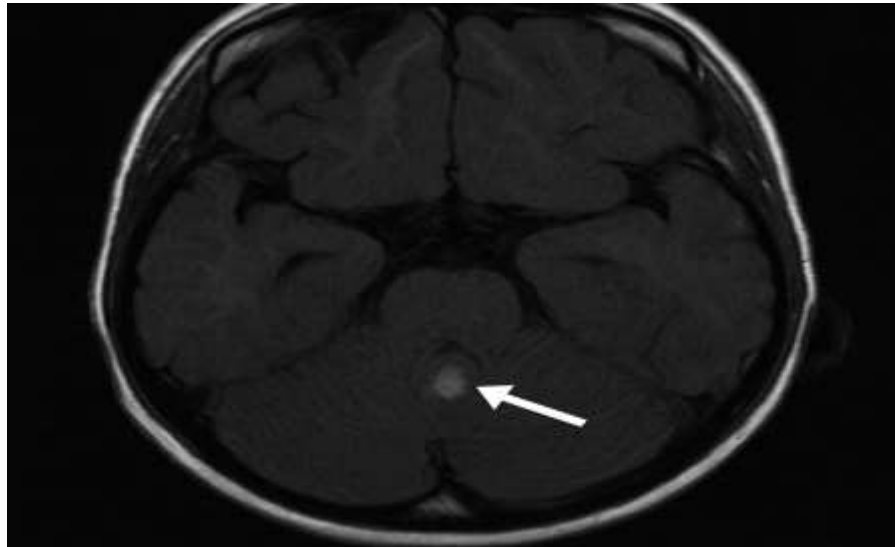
Axial MRI of a pediatric medulloblastomas
